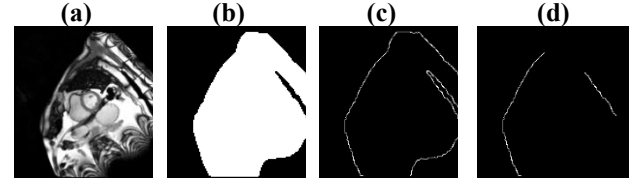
(a) Raw MR image – input for both networks, (b) torso segmentation – output for first network, (c) full contour – extracted from the output of the first network and used as additional channel input for second network, (d) contour segmentation with arm and false lower boundary removed – output for second network.
